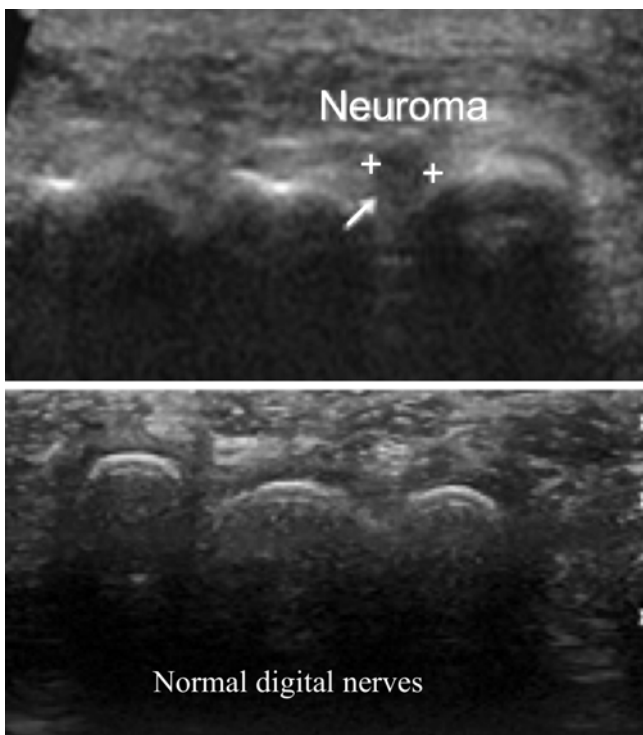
Ultrasound evaluation of digital neuroma; *lower image* shows normal digital nerves, while *upper image* shows displacement of the neuroma with lateral squeeze (Image courtesy of Michael Brown, MD)
